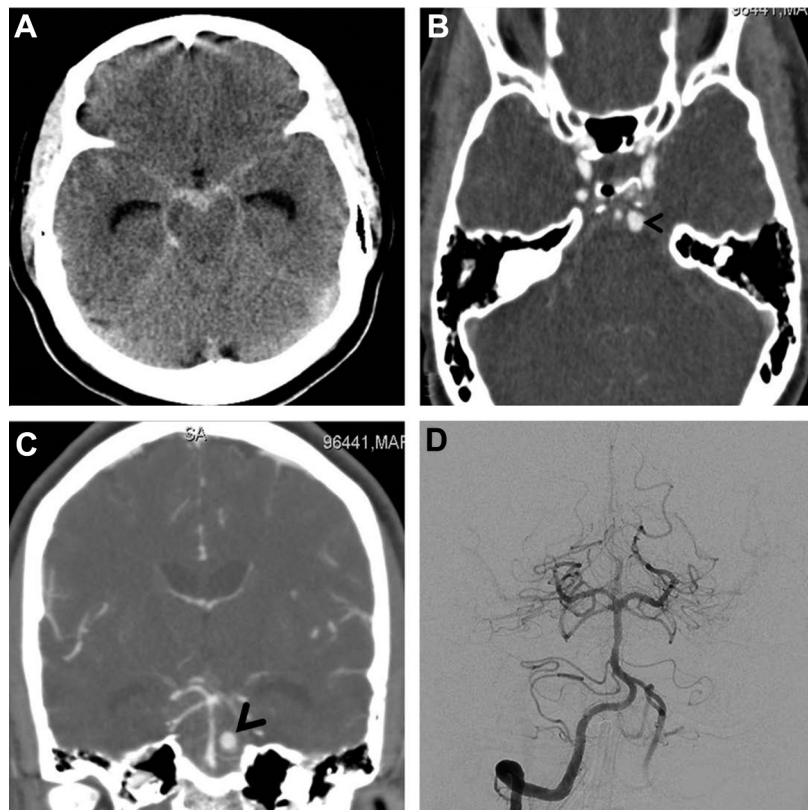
A. Non-contrast brain CT-scan: subarachnoid haemorrhage and dilated temporal horns of the lateral ventricles. B, C. Initial angio-CT-scan, axial (B) and coronal (C) views: left-sided 6-mm long circumferential BA branch aneurysm (black arrow head). D. Cerebral conventional angiography: patent left AICA, occlusion of the left BA long circumferential branch and no evidence of any aneurysm.
